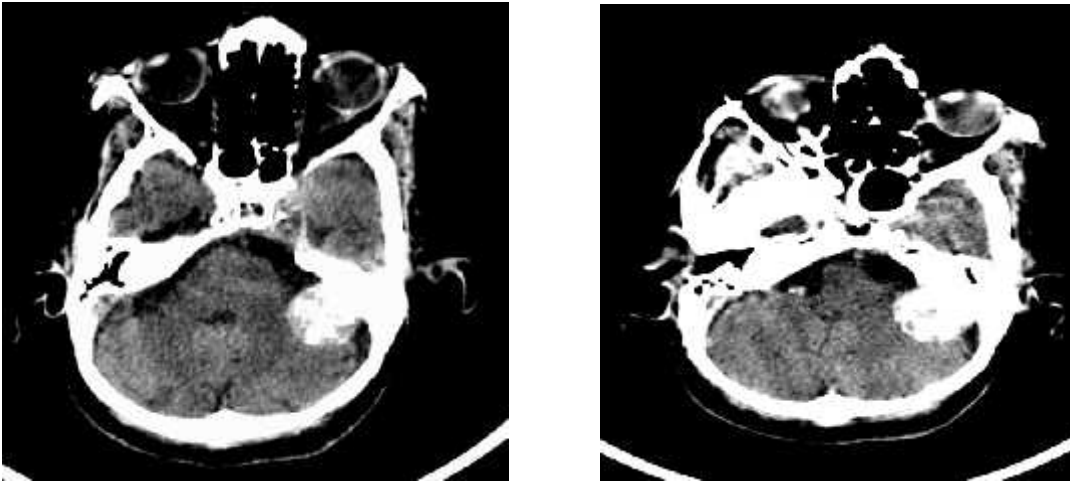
HRCT AXIAL Brain window shows evidence of well defined mass lesion broad based towards dura in the region of left cerebellopontine angle with calcifications within and enhancement on post contrast study.
